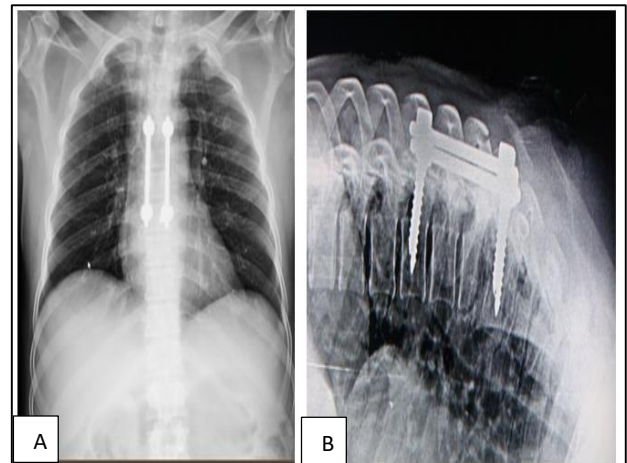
(A and B): Post operative radiograph showing fixation from T3-T6. Antero-posterior and lateral view showing a posterior spinal construct with pedicle screws at T3 and T6 level connected by a rod.
